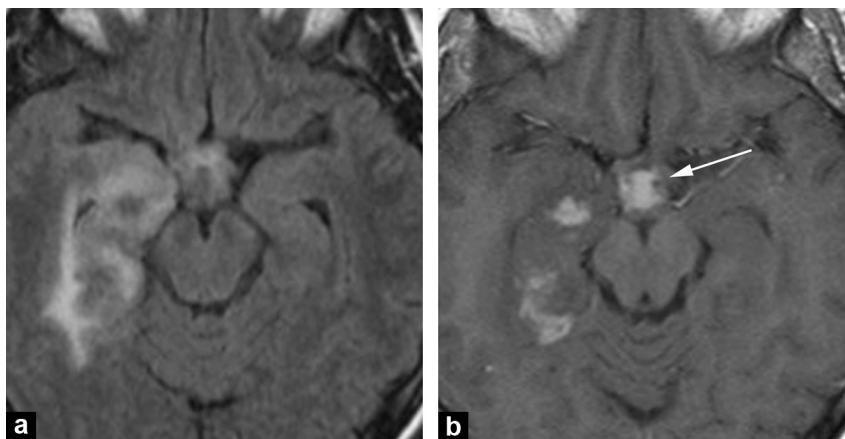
Neurosarcoidosis. FLAIR axial (a) and T1 after injection of gadolinium (b). Parenchymatous lesions, which appear right internal temporal pseudotumoral, in FLAIR hypointense, enhancing homogeneously after injection and surrounded by oedema in FLAIR hypersignal. Associated hypothalamic infiltration, enhanced after injection.
